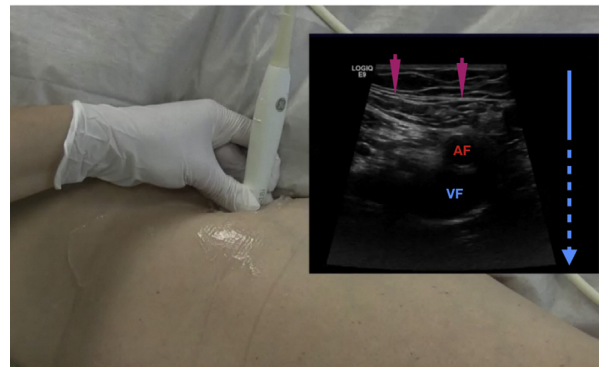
An 18 MHz sonogram of the thigh shows the attenuation of the ultrasound waves with increasing depth as a loss of brightness in the inferior part. The different layers of the fascia lata can be clearly depicted. Magenta arrows: fascia lata, AF: femoral artery, VF: femoral vein. The blue arrow exemplifies the attenuation of the ultrasound beam.
